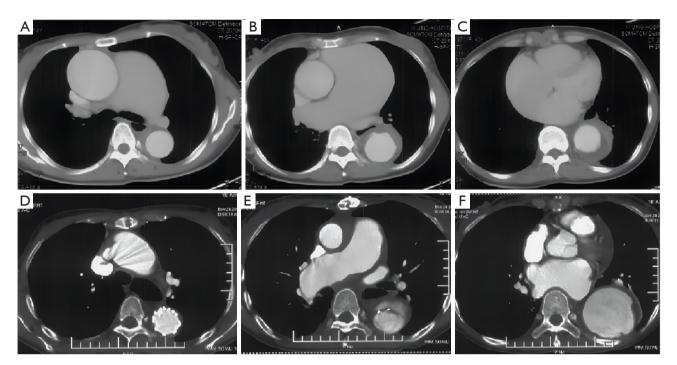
Marfan syndrome. (A-C) Contrast-enhanced CT examination in patients with Marfan syndrome shows simultaneous dilation of the ascending aorta and the main pulmonary artery and intramural hematoma of the descending aorta. (D-F) CT reexamination 3 months after thoracic aortic arch stenting shows that the descending aorta tube diameter is significantly wider than that reported the previous time with dissection. CT, computed tomography.
